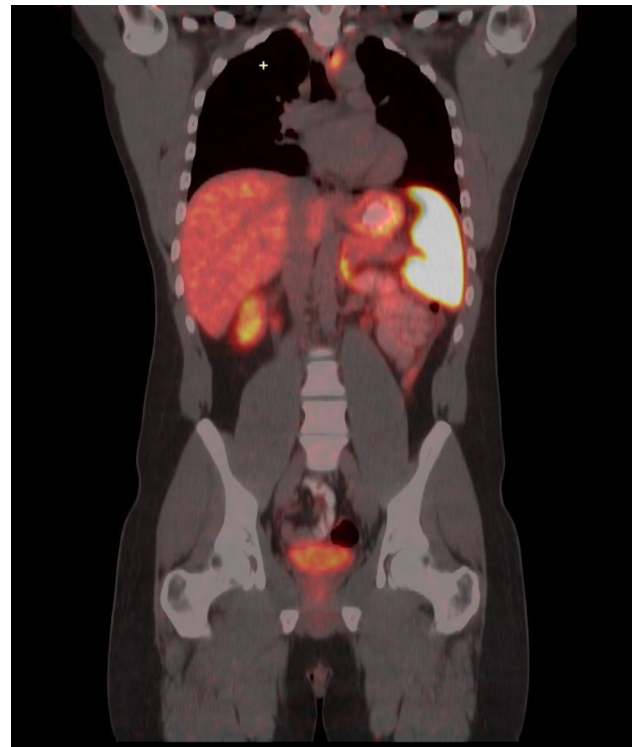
Ga 68 DOTATATE PET/CT showing increased left mediastinal uptake in a patient with medullary thyroid cancer
